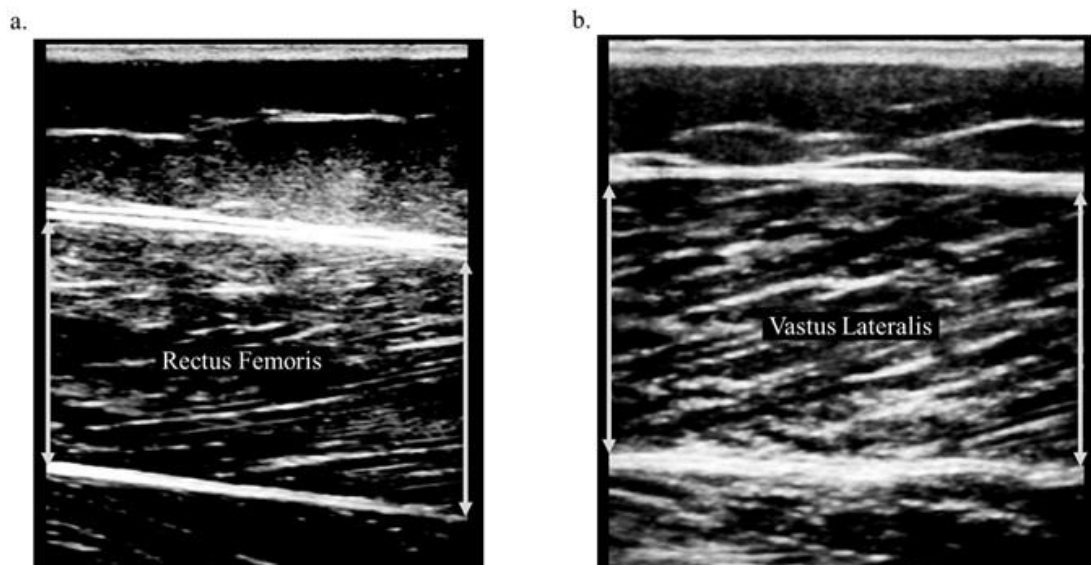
Ultrasonography images of (a) rectus femoris (RF), and (b) vastus lateralis (VL). Arrows indicate muscle thickness measurements for distal (left) and proximal (right) of each image.
